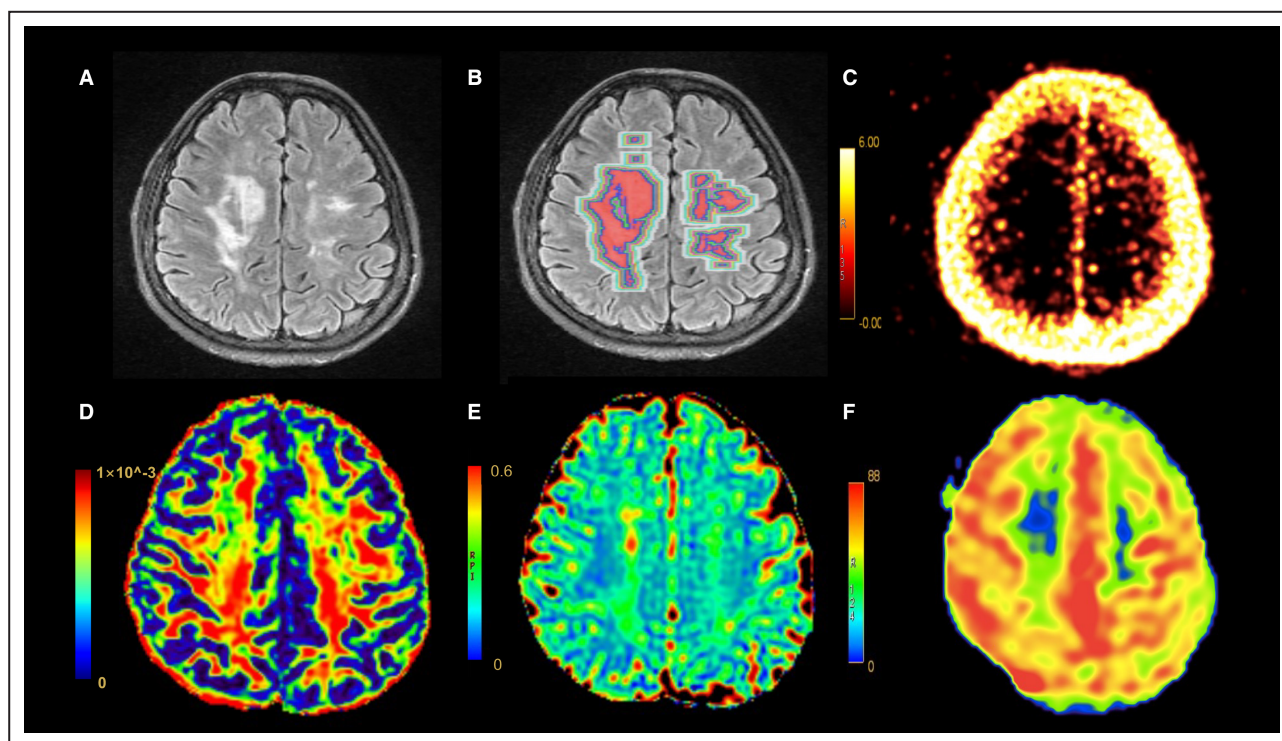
^{68}Ga -NOTA-PRGD2 PET/MRI.
